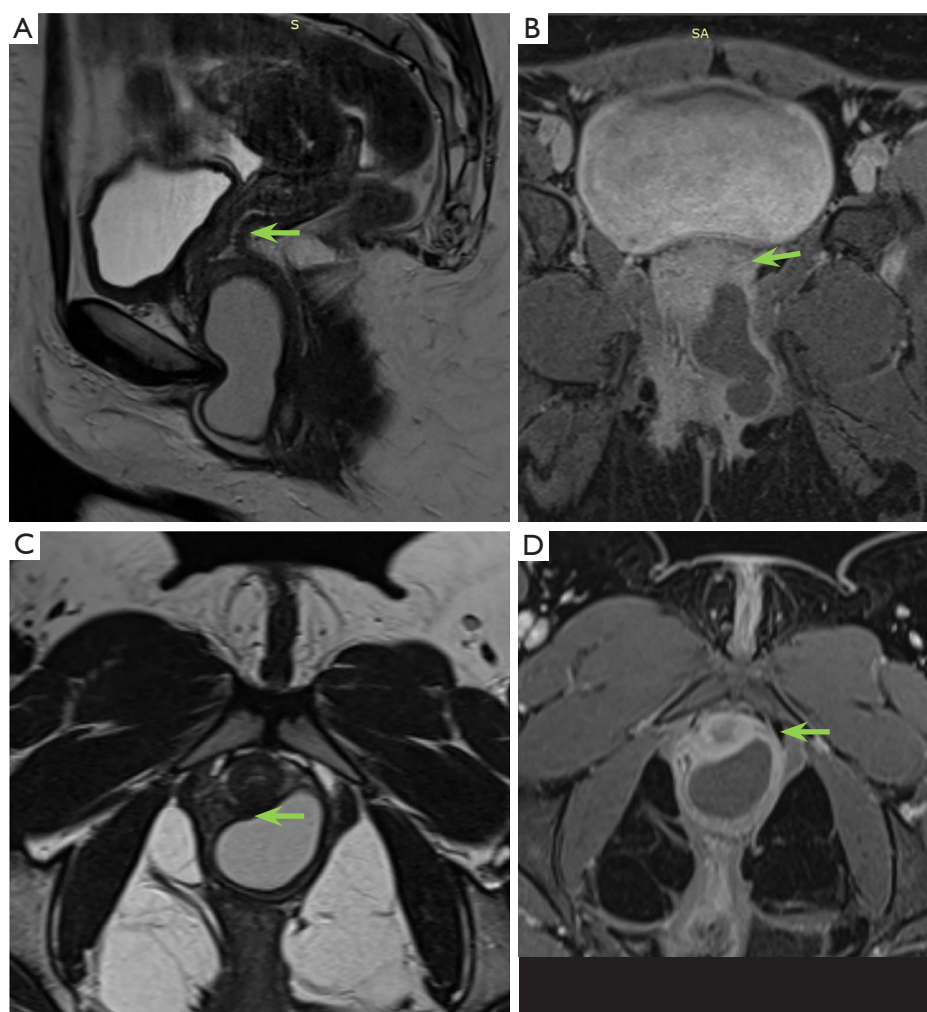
Gartner's duct cyst on contrast-enhanced pelvic MRI. Multilobulated cystic lesion (green arrows) in the anterosuperior vaginal wall, hyperintense on T2 (A,C), hypointense on fat-saturated T1 (B,D), with subtle wall enhancement. MRI, magnetic resonance imaging.
